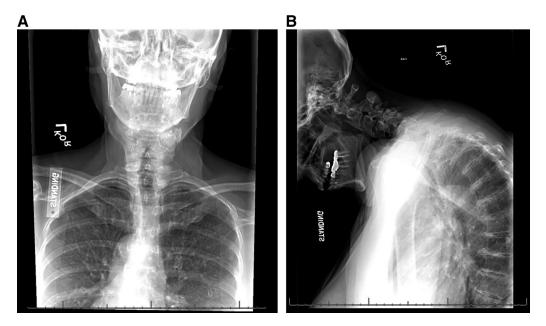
A, 1B Pre-operative AP (1A) and Lateral (1B) view radiographs were notable for gross spondylosis throughout the cervical spine with a 4.6 mm subluxation of C4 on C5 on upright views.
